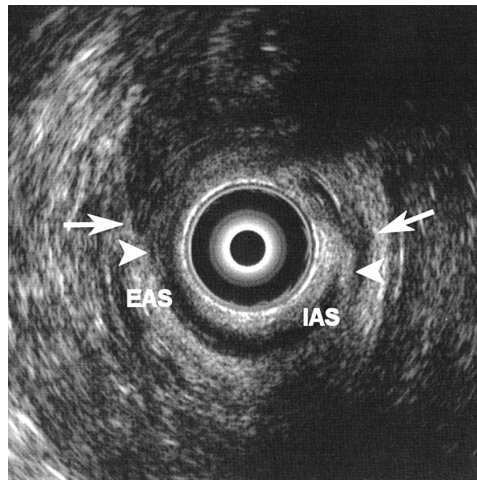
Endoanal ultrasonography of a 55 year-old female with a complicated vaginal delivery in the past and a large external defect at digital rectal examination. This finding was confirmed at endoanal ultrasonography, revealing disruption of the full length of the external anal sphincter muscles over 180 degrees (white arrows). Arrow heads show a large defect of the internal anal sphincter. The top of the figure is anterior.
